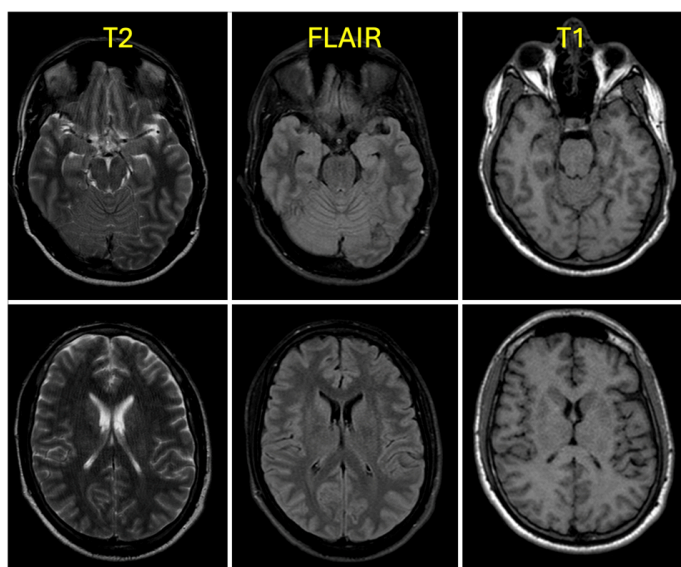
Brain MRI with no major findings
